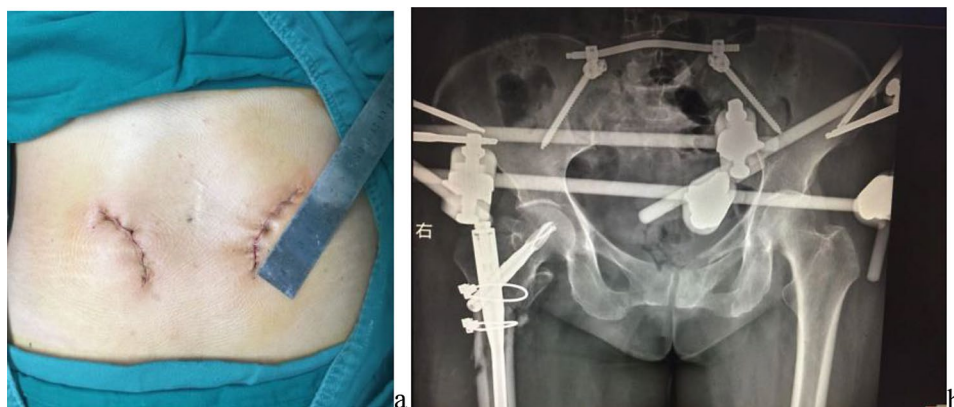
Posterior surgical incisions for screw-rod fixation (a). Postoperative plain X-ray showed anteroposterior appearance (b)
